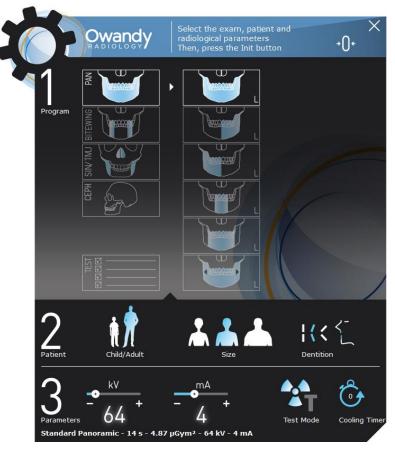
Panoramic X-ray range
